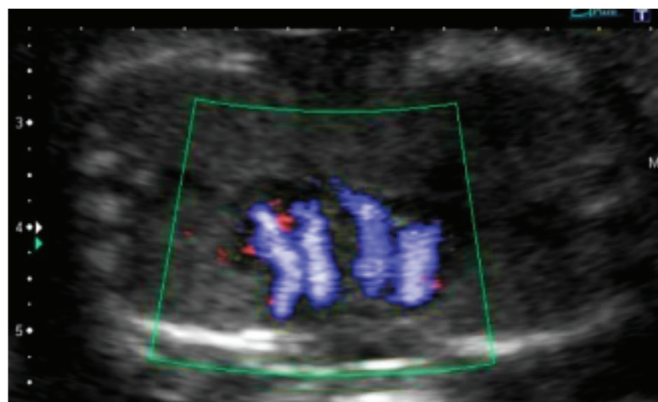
Color Doppler on atrioventricular valves in thoracopagus twins.
